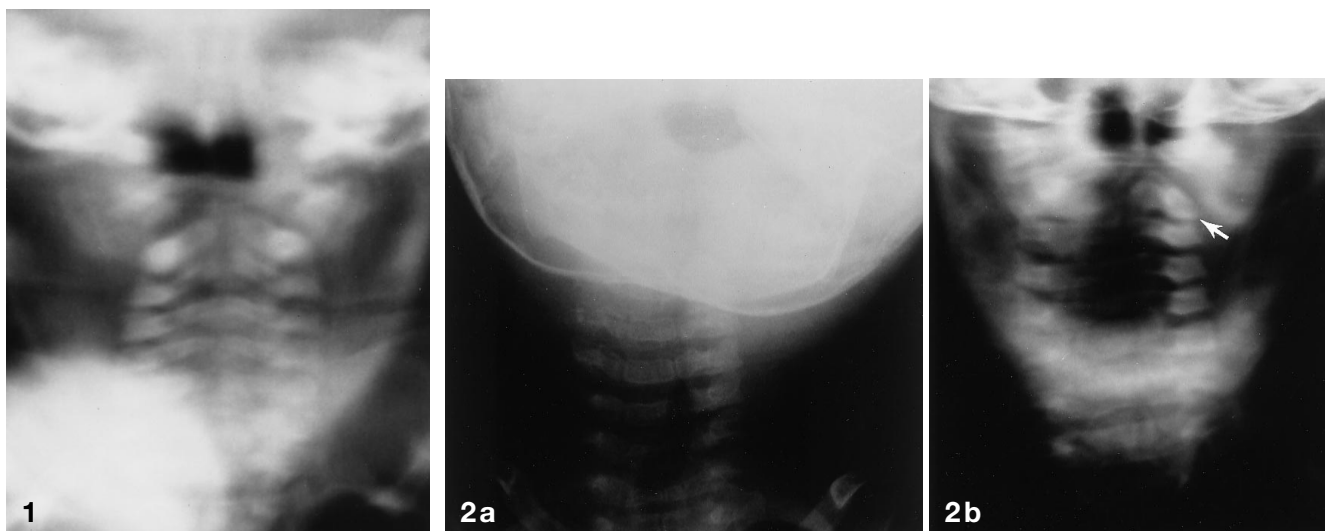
Head wag radiograph of a normal infantile cervical spine. The C1 lateral masses are the most blurred, since most of the rotation is occurring at C1. The radiographic tube was not angled in relation to the tabletop, which allows optimal visualization of the neural arches in the infant. The pacifier is seen overlying the lower right cervical spine
